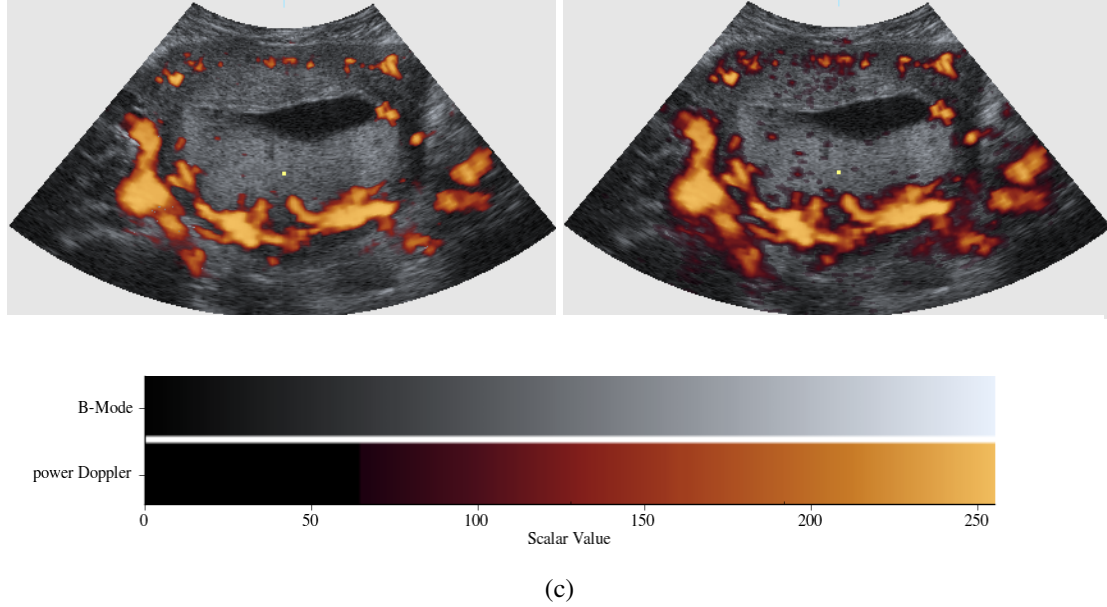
Slices of placenta showing differences in opacity values of the PD colour map. Adjustment of lower bound of palette shows additional Doppler information visualised when comparing 5.2a with 5.2b. Figure 5.2c shows typical colour maps for B-mode and PD modalities with scalar values indicating the minimum, maximum and value at which PD appears.
